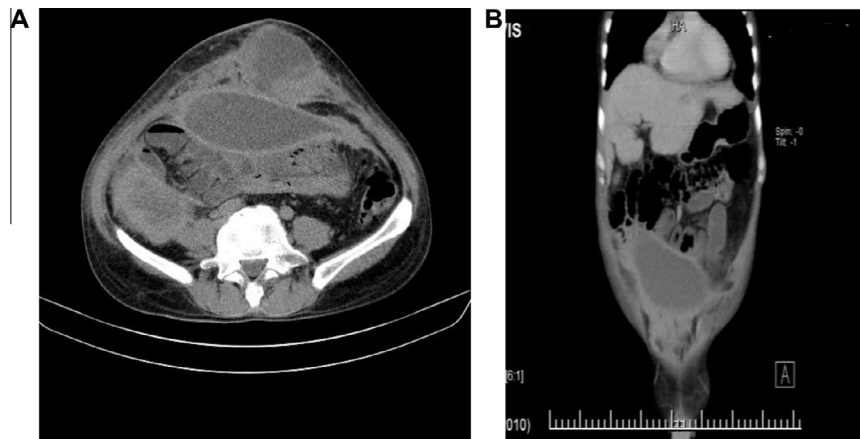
(A and B) 55-year-old man with diffuse abdominal pain. Axial (A) Coronal (B) CT reformation of MDCT scan with oral and IV contrast shows pelvi-abdominal encysted fluid with uniform mural enhancement consistent with abscess formation.
